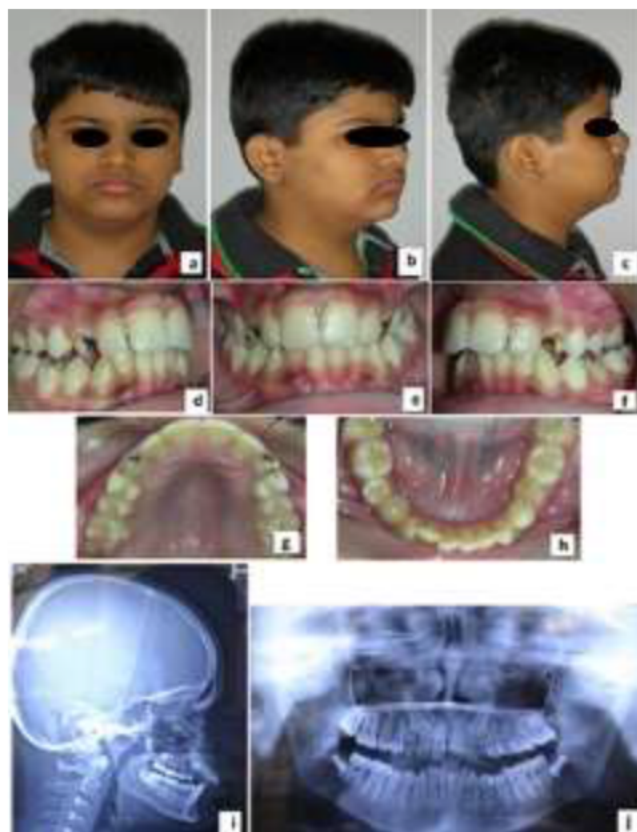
Mid - treatment extraoral photographs (a- c), Mid -treatment intraoral photographs (d-h), Mid -treatment lateral cephalogram (i), Mid-treatment orthopantomogram (j).
